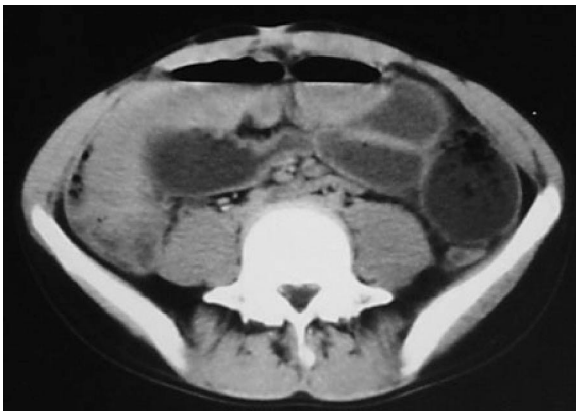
CT examination revealed the presence of distended jejunal and ileal bowel loops. Colonic loops were not dilated and were partially compressed by fluid-filled intestinal loops. The findings suggested the diagnosis of ileus due to obstruction at the ileal level but the cause of the obstruction could not be demonstrated.
